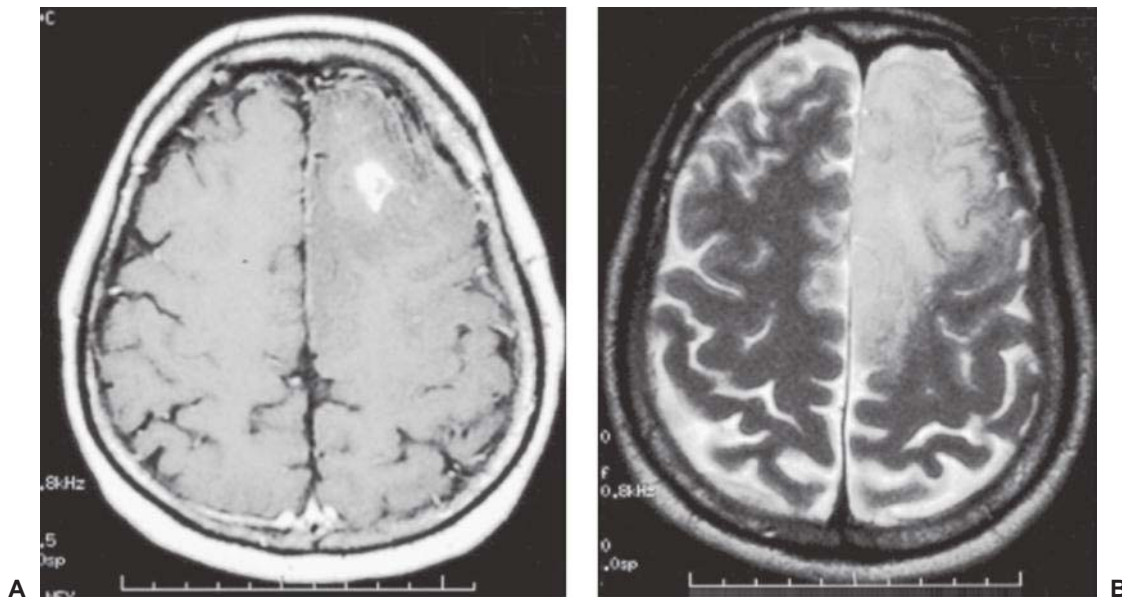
A: Low-grade astrocytomas often do not enhance and contrast-enhanced T1-weighted magnetic resonance sequences considerably underestimate the true infiltrative extent of these neoplasms. B: The fluid-attenuated inversion recovery (FLAIR) sequence is considerably more useful in appreciating the true extent of such neoplasms.
